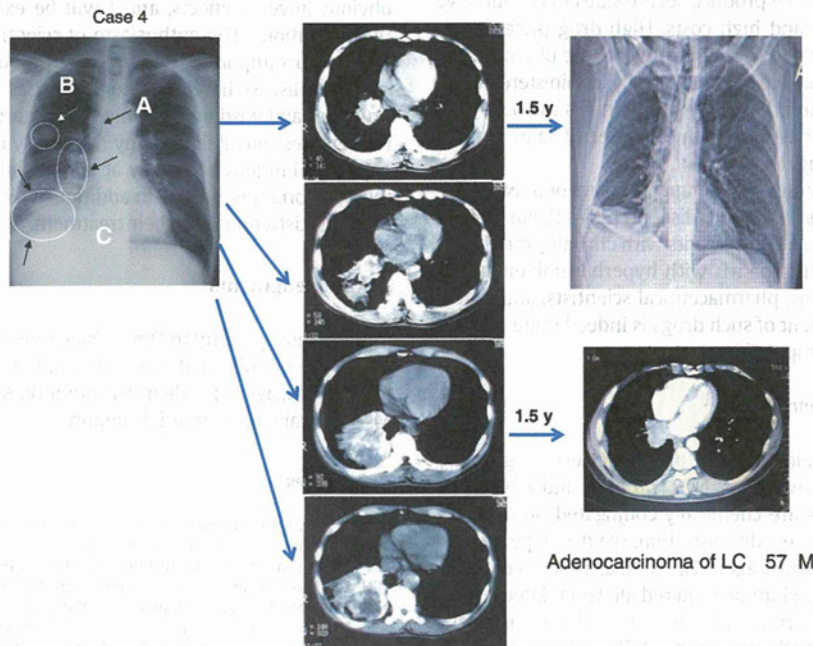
Case 4. Lung adenocarcinoma. (Top left) Initial chest X-ray showing multiple tumors A, B, and C (circled areas, arrows). The patient underwent Nitrol infusion followed by SMANCS/Lipiodol infusion of 0.5 mg/0.5 ml into both bronchial arteries, as in Case 3. (Middle) CT scans from the subscapular to the lower pleural cavity at the time of initial infusion. (Right) Both chest X-ray (top) and CT scan (bottom) show remarkable tumor regression after 1.5 years; and the patient had no subjective complaints during this period.
